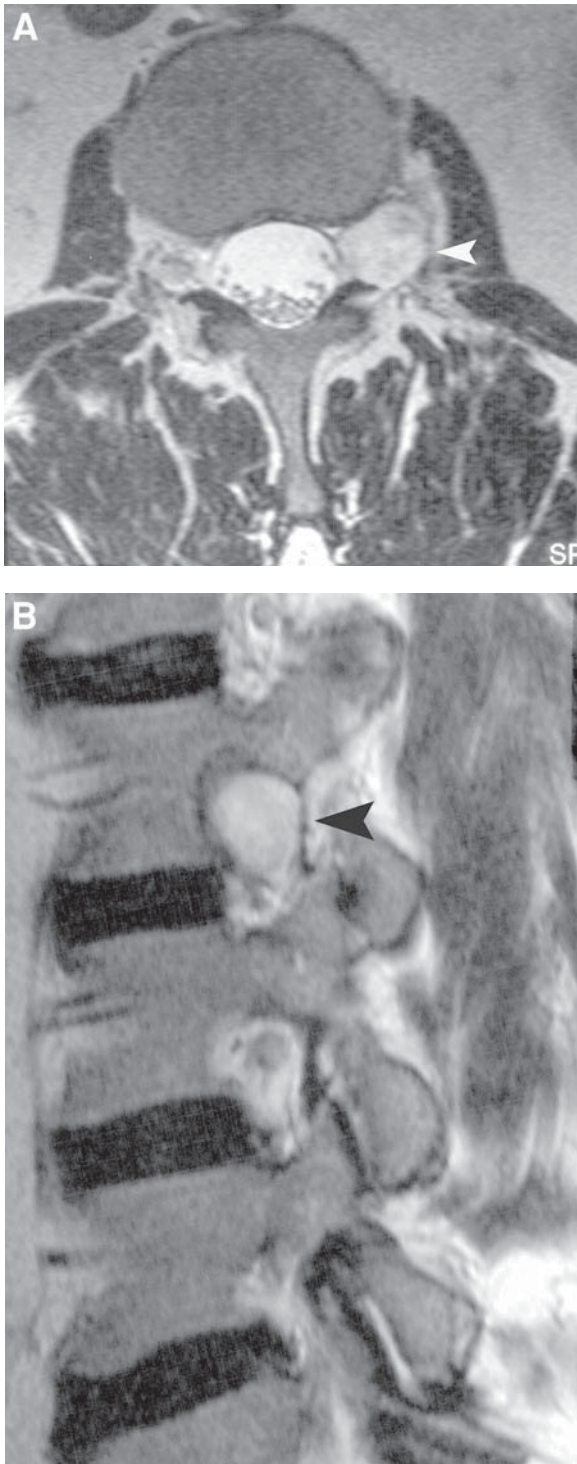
Schwannoma. An expansile foraminal mass is identified in the left neural foramen on the axial (A) and sagittal (B) T2-weighted images. The mass is well defined and shows primarily high T2 signal with additional areas of low signal intensity.
